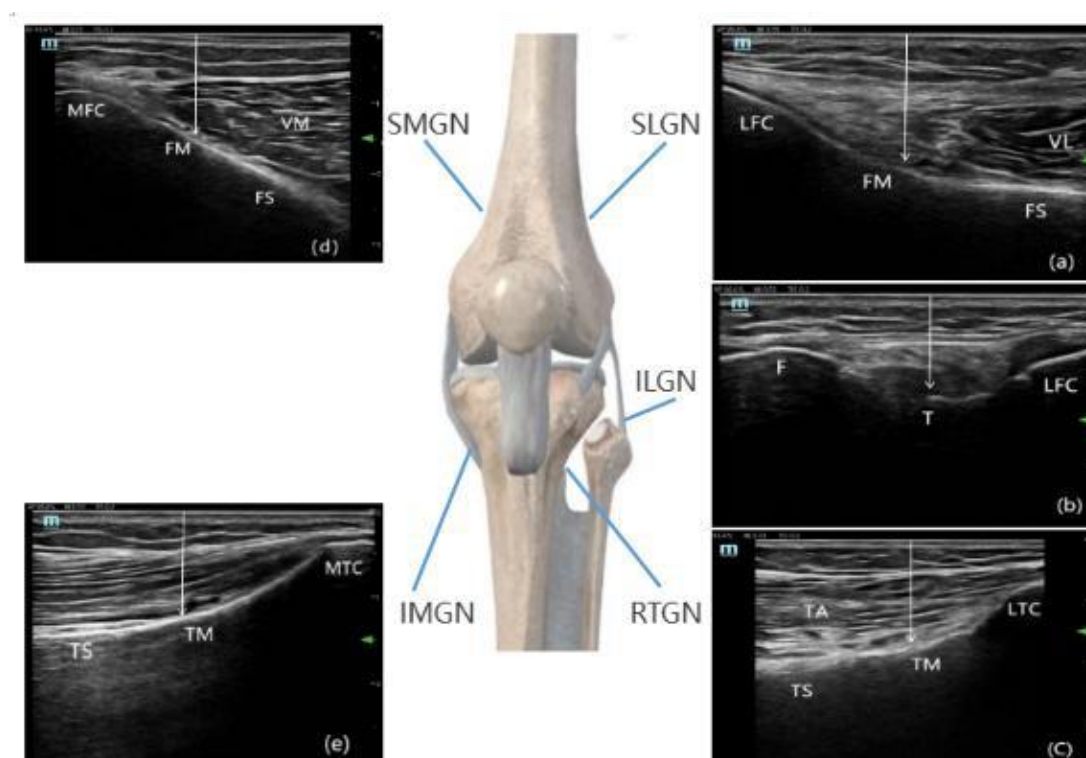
Ultrasound-Guided Genicular Nerves Block
